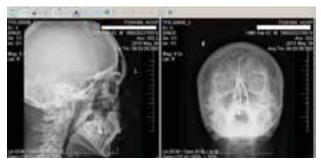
Radiography of skull after displaced screw extraction. Shows position of the orbital arcade plaque.
